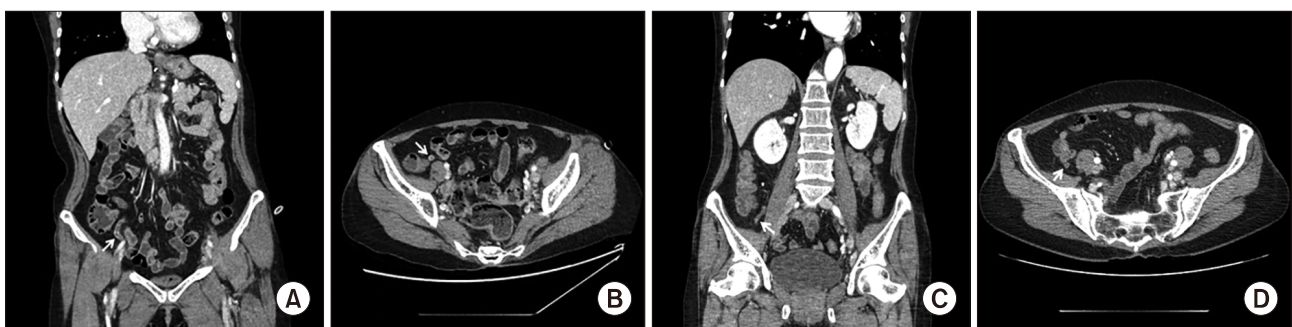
Abdominal computed tomography (on hospitalization day 1) images of a fluid-filled, dilated appendix with prominent mural enhancement, indicating inflammation, but no periappendiceal fat infiltration (white arrows). (A) Coronal view. (B) Axial view. Abdominal computed tomography (on hospitalization day 7) showed no evidence of appendix inflammation (white arrows). (C) Coronal view. (D) Axial view.
